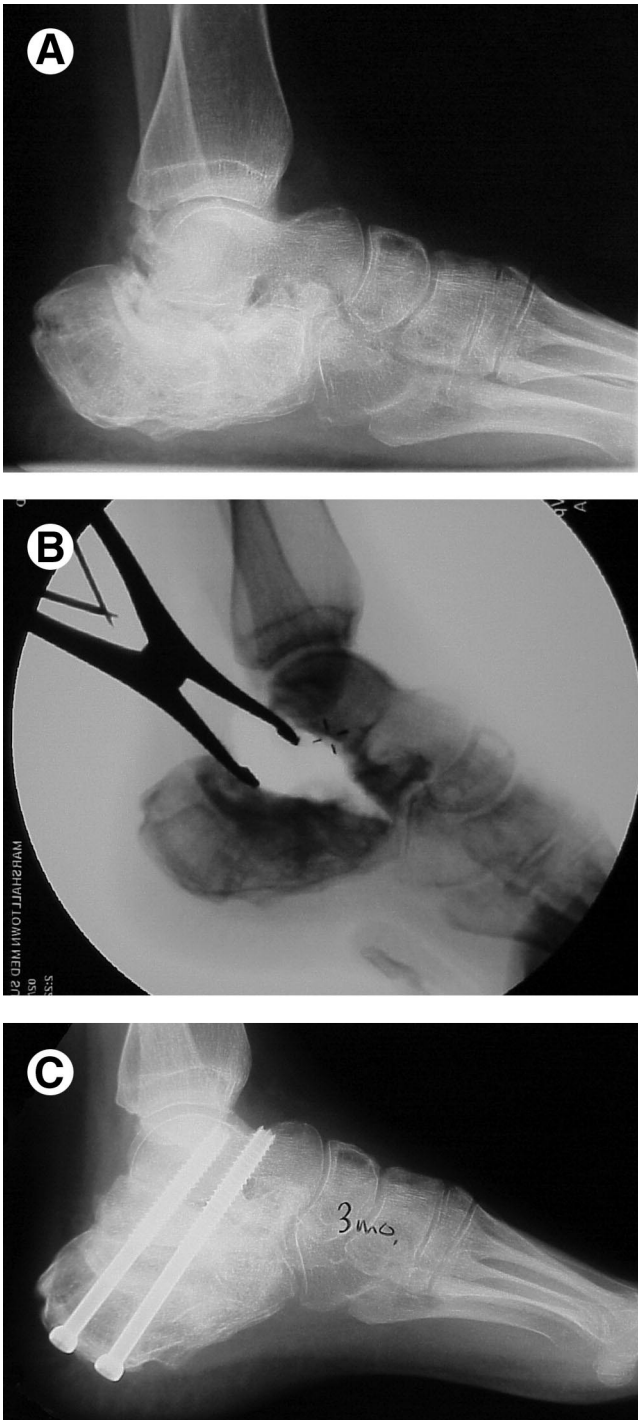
This patient sustained a joint depression calcaneal fracture, resulting in a painful flatfoot deformity, shown in (A) this lateral radiograph. The foot was reconstructed with a bone graft subtalar fusion. (B) An intraoperative image shows the technique of distracting the subtalar joint, which was followed with rigid internal fixation with 2 large cannulated screws, shown on (C) the postoperative lateral radiograph.
